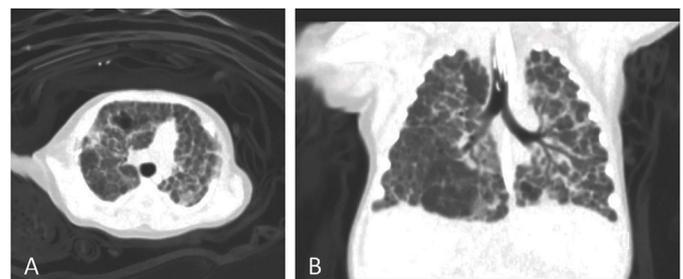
CT of the chest without contrast, axial (A) and coronal (B) demonstrate mild hyperinflation of the right greater than left lung with a mosaic lung parenchymal pattern. Areas of low attenuation and focal air trapping are noted, along with associated bronchial wall thickening. Small subpleural triangular/linear opacities are also seen. CT, computer tomography.
